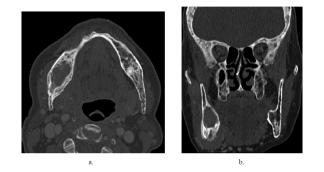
(case 18). Plasmacytoma and multiple myeloma in a 72-year-old female patient. (a) Axial and (b) coronal maxillofacial computed tomography showing hypodense, lytic mass (plasmocytoma) extending from the level of the right mandible angulus to the mandible corpus and causing destruction in the mandible. Diffuse lytic lesions (multiple myeloma) in all calvarial bone structures.
